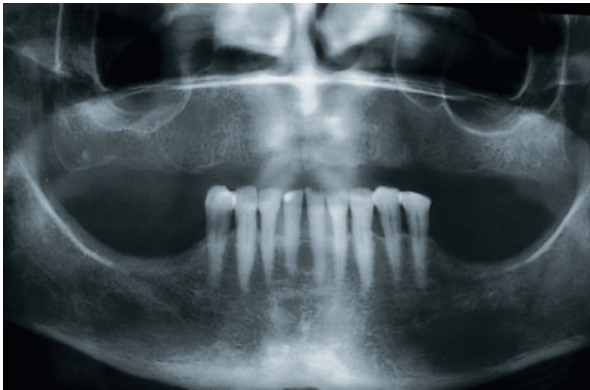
The corresponding panoramic radiograph reveals – at least as far as the vertical bone volume is concerned – favorable conditions in view of implant therapy in both the upper and the lower posterior jaw.
